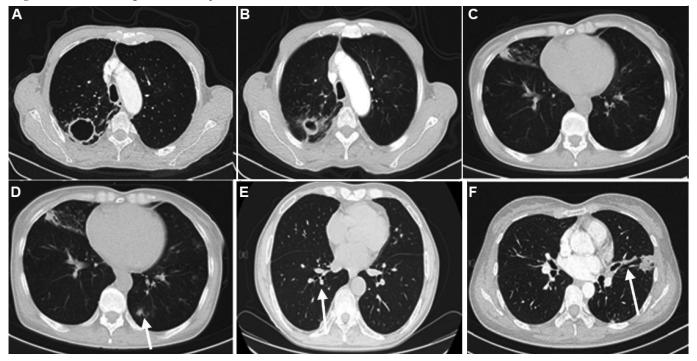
Partial CT images of NTMPD patients.
